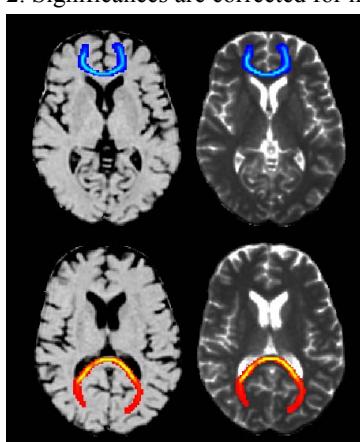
Genu (blue) and splenium (red) of the corpus callosum segmented from diffusion MRI data and registered to MTR (left) and T1 (right) maps.
